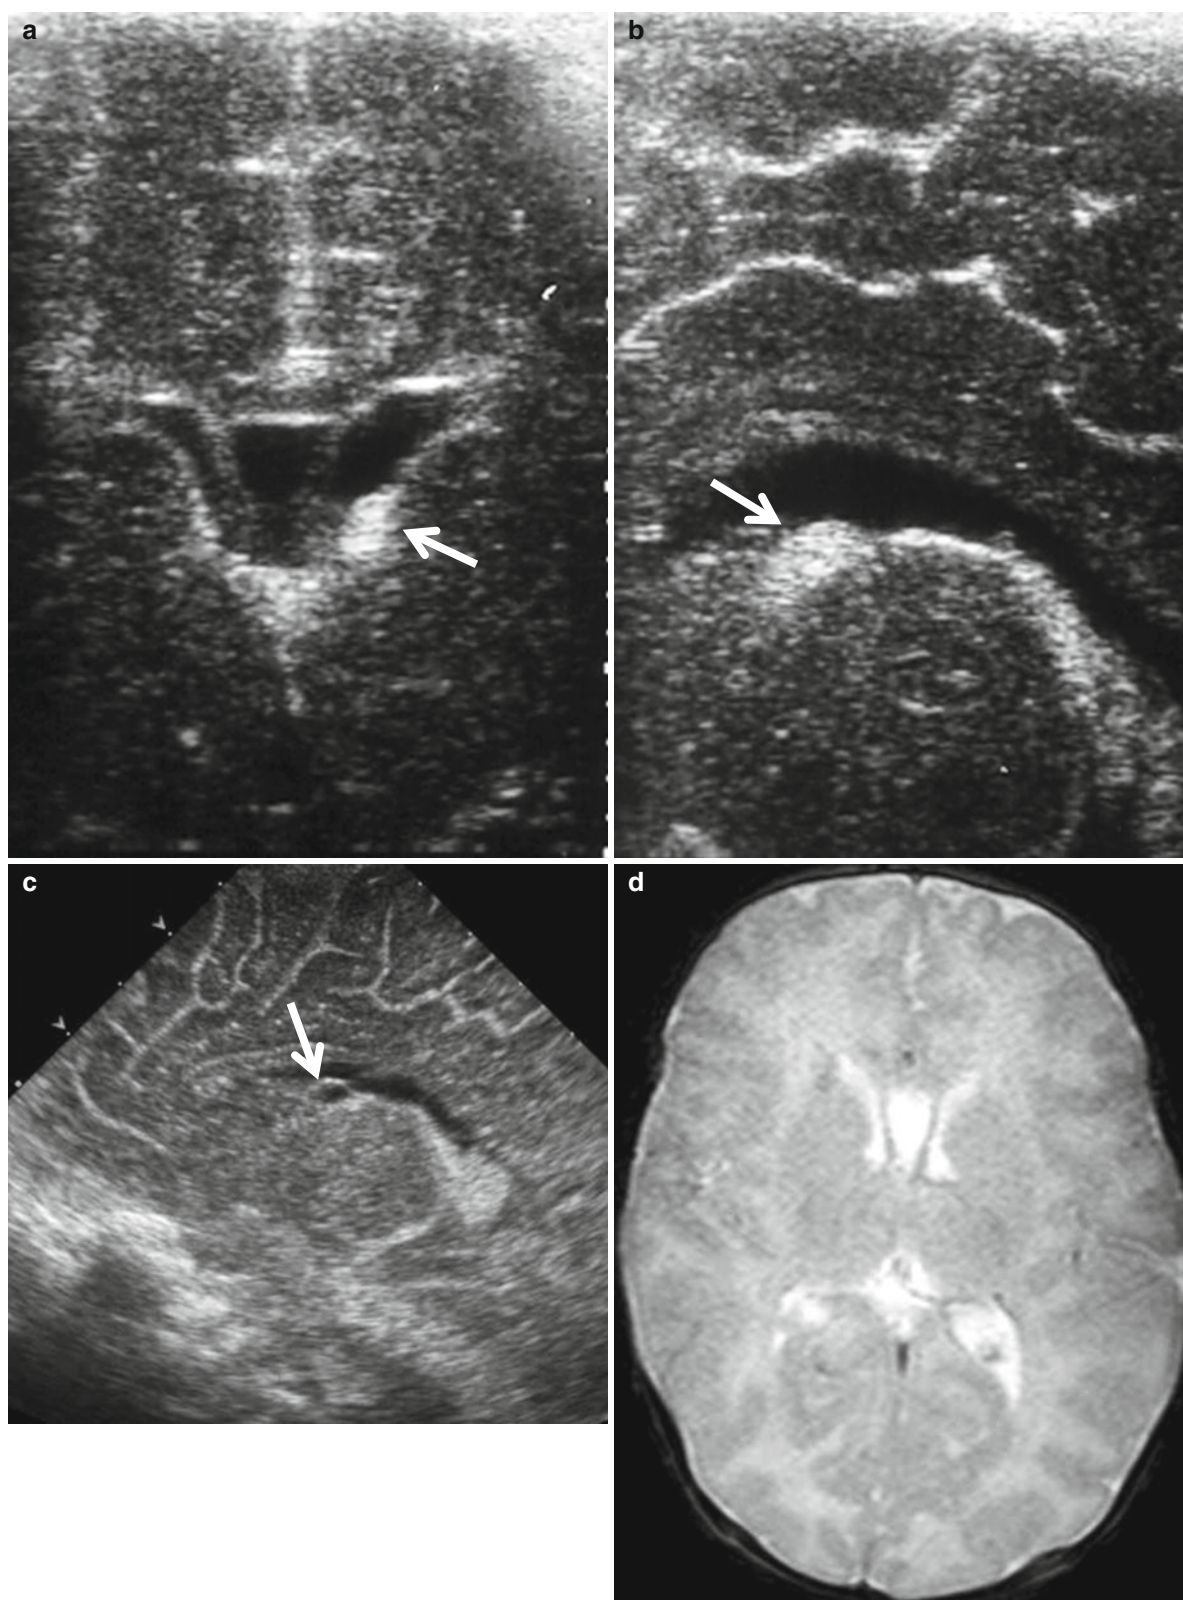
Germinal matrix hemorrhage on US and MR images. (a, b) US obtained at 4 days of life reveals focal echogenic bulging (*arrow*) at the left caudothalamic groove (ganglionic eminence). (c) Cystic change
